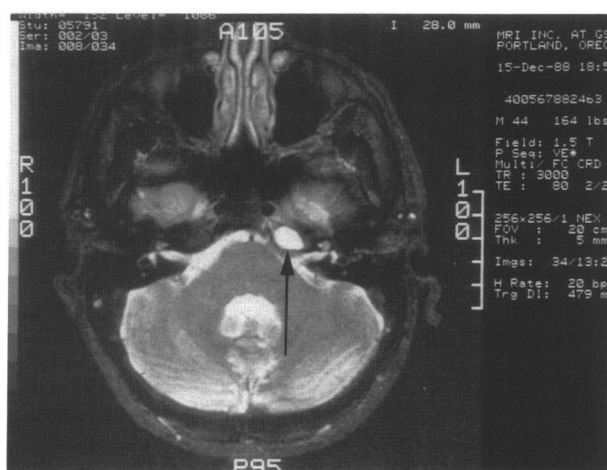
Magnetic resonance image, T₂-weighted. Arrow indicates enhanced cholesterol granuloma in anterior petrous pyramid. Note absent enhancement on the left.
